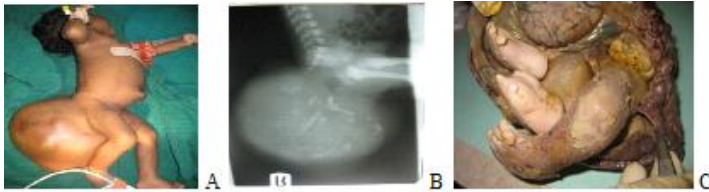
A. Huge sacrococcygeal teratoma (SCT), B. Plain radiography showing cartilaginous and bony tissue in the SCT, C. Post excision photograph showing multiple legs and foot, brain tissue and bowel in the mass
